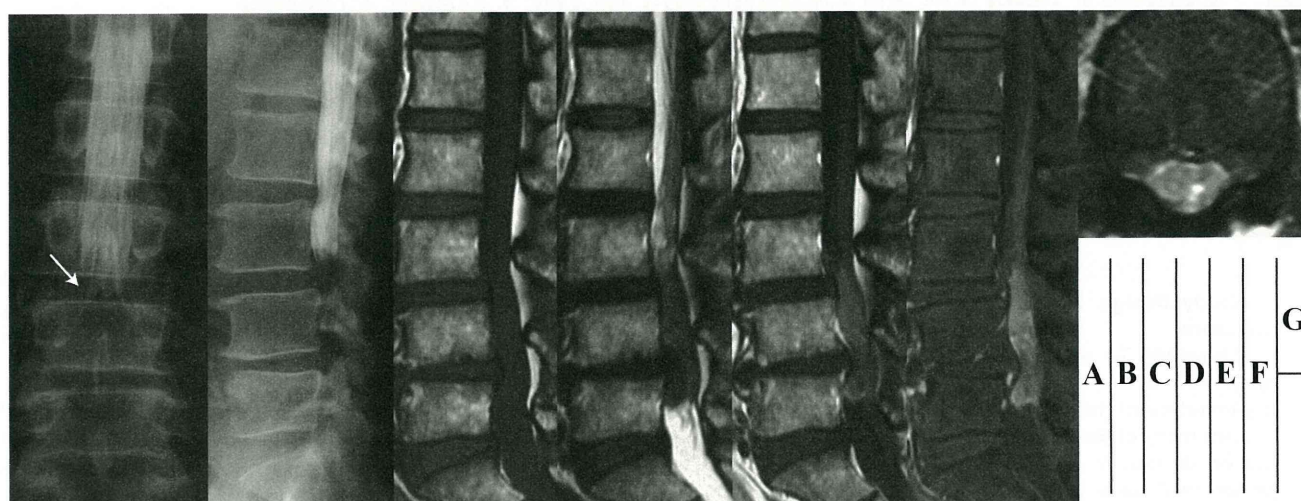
Myelography—(A) posteroanterior, (B) lateral—showing a complete block at L3/4, and nodular thickening of the lumbar nerve roots (arrow). Magnetic resonance imaging—(C) T1-weighted sagittal image, (D) T2-weighted sagittal image, (E) T1-weighted sagittal image with gadolinium enhancement, (F) T1-weighted and fat suppression sagittal image with gadolinium enhancement, (G) T1-weighted and fat suppression axial image with gadolinium enhancement at L4—showing an intrathecal mass at the lesion and marked enhancement with gadolinium.
